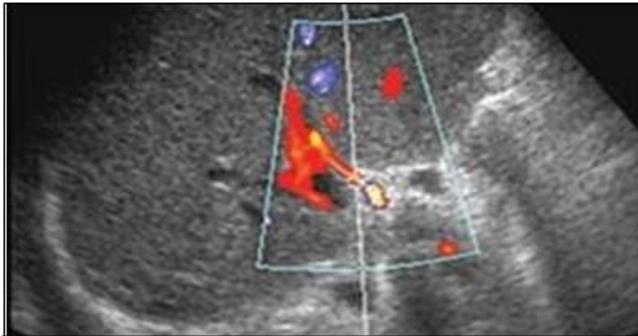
Color flow mapping of the hepatic artery Day 1 post-operatively showing the anastomotic and intra-graft HA course. Power Doppler shows
